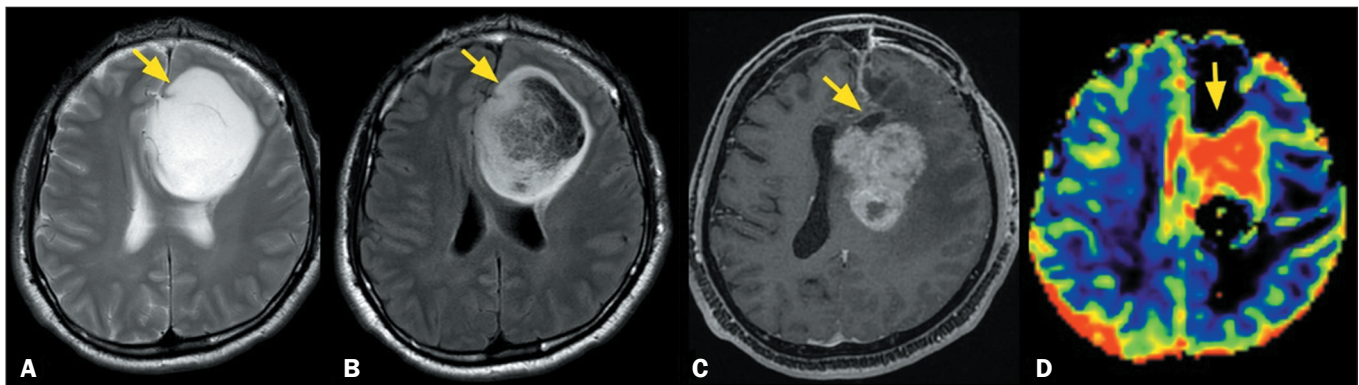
MRI scans of a 25-year-old male patient. A T2-weighted sequence (A) and a FLAIR sequence (B), both acquired in 2010, showing an infiltrative lesion, with high signal intensity and a T2-FLAIR mismatch sign (arrows), in the left frontal lobe. After surgical resection, the patient received a diagnosis of IDH-mutant grade 2 astrocytoma. A follow-up examination in 2021 (11 years later) showed enlargement of the remaining lesion. At that time, a fat-saturated T1-weighted sequence (C) showed areas of intense contrast enhancement in the solid areas (arrow) and a dynamic T2* perfusion-weighted sequence (D) showed high rCBV (arrow on color map), both findings being consistent with transformation to high grade. After a second surgical resection, a diagnosis of IDH-mutant grade 4 astrocytoma was made. No 1p/19q codeletion was observed.
